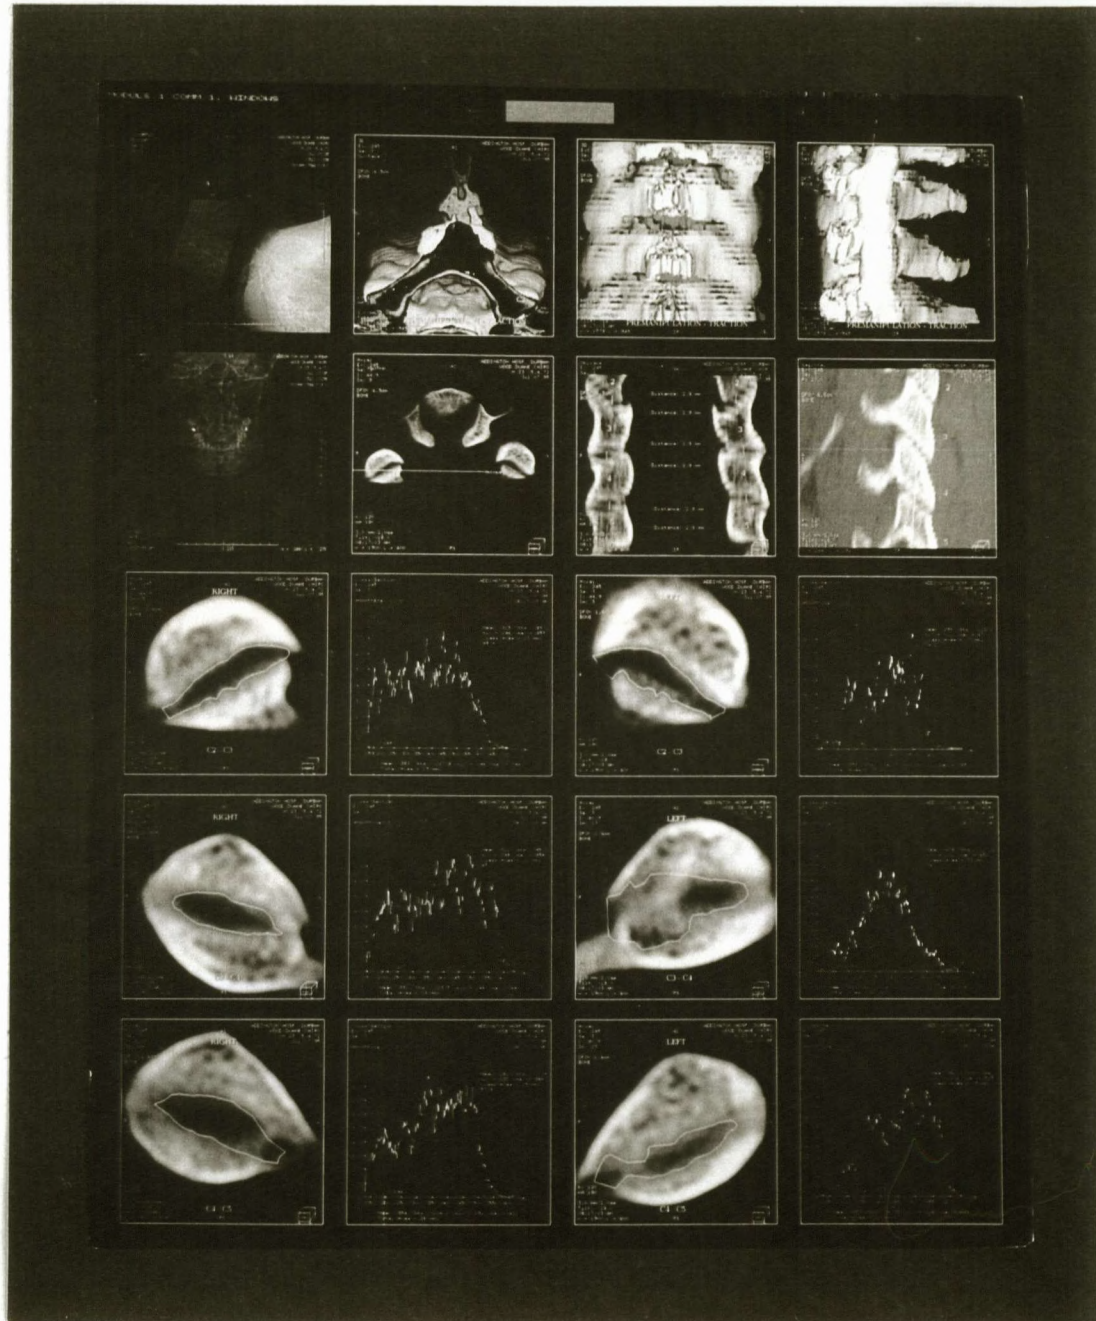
Experiment 4 : Post-manipulation CT scan
